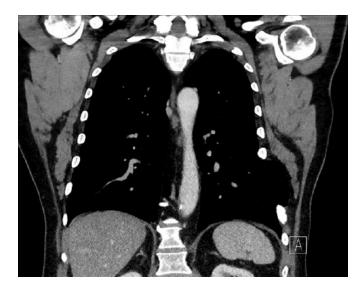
Contrast-enhanced CT of the chest two years postoperatively showing an intact left diaphragmatic repair
